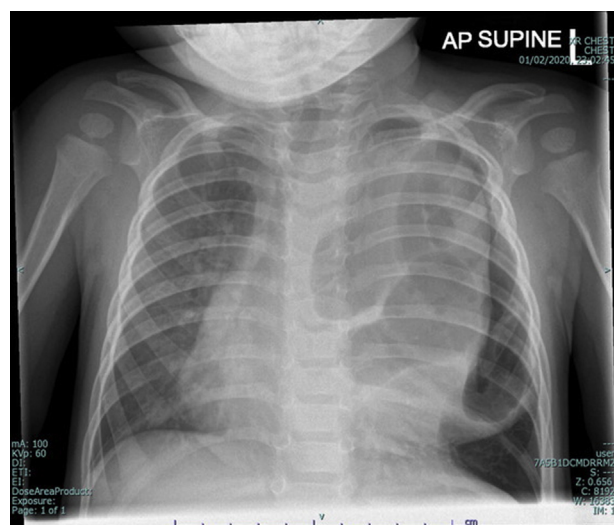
Chest radiograph showing the unusual cystic lesion.
